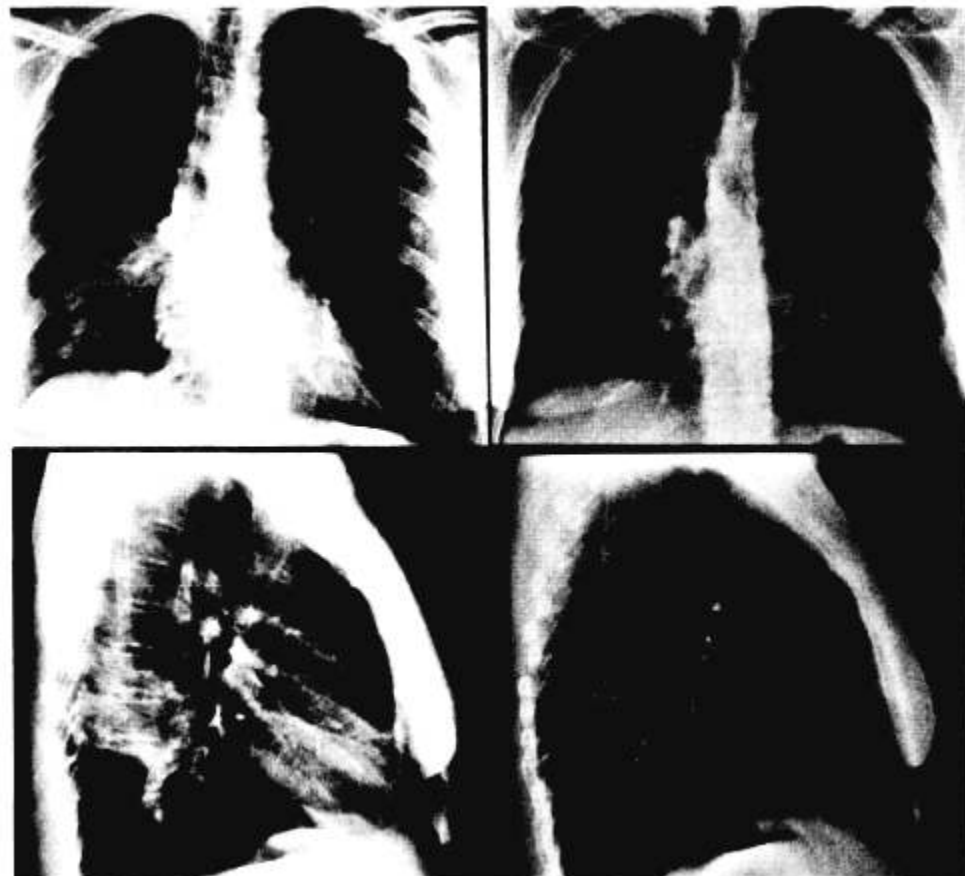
Left top and bottom panels: pretreatment PA and lateral chest radiographs showing a large right lower lobe parahilar metastasis. Right top and bottom panels: a partial response was observed following 3 months treatment with 13-*cis*-retinoic acid plus IFN- α .
